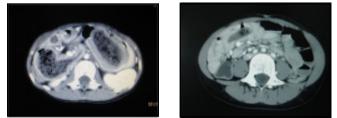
Axial CT Scan Showing Extension of Mass into Duodenal Loop & Detached Portions of Mass in Small Bowel Loop.
